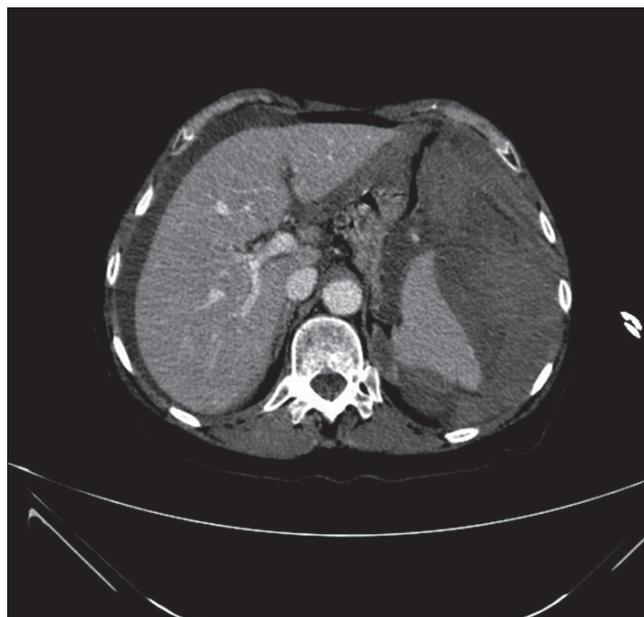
CT: Splenic-capsule-depending hematoma of 15x7 cm. Free liquid in the abdominal cavity was also noted. It revealed a large, splenic-capsule-depending hematoma in the left hypochondrium. Free liquid in the abdominal cavity was also noted.
